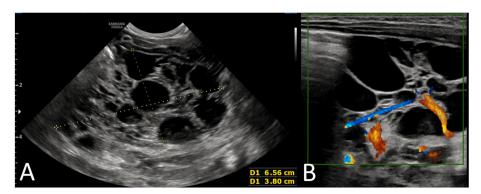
A) Sonographic aspect of 5-month-old girl's lymphangioma B) Colordoppler exam showing major vessels encased in the lesion.
